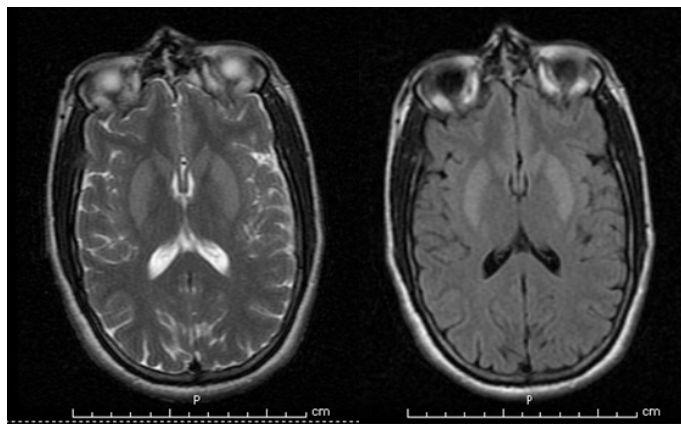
T2-MRI (left) and FLAIR MRI (right) taken within five days of the patient's cardiopulmonary arrest revealed high signals involving the putamen and caudate bilaterally, indicating ischemia.
